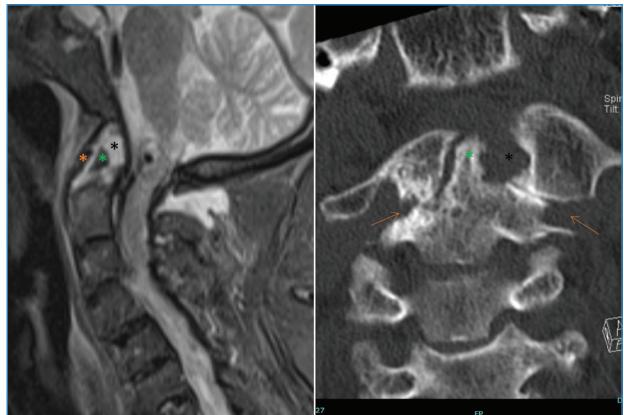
Sagittal T2 STIR MRI sequence (left image) showing severe inflammatory pannus (black asterisk) with erosive destruction of the odontoid process (green asterisk); coronal CT scan (right image) showing dislocation of the C1-C2 lateral joint masses (arrows).
